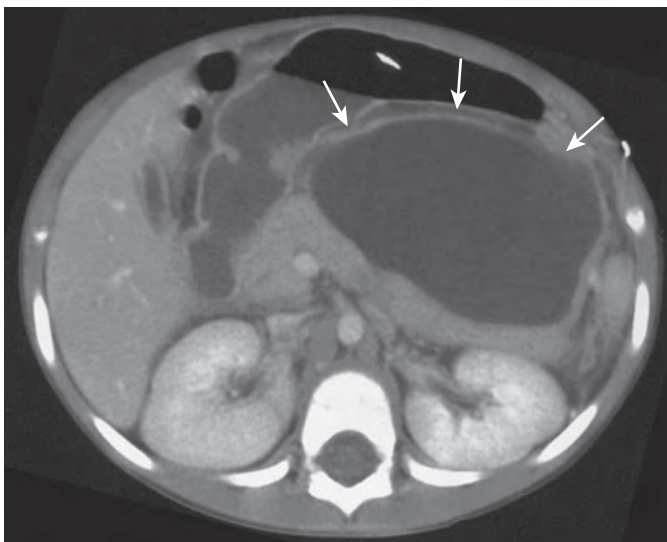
Pancreatic pseudocyst. The CT scan through the pancreas shows a large cystic fluid collection in the midabdomen with a mass effect on the stomach that represents a pseudocyst (arrows) in a young patient with a history of pancreatitis.
